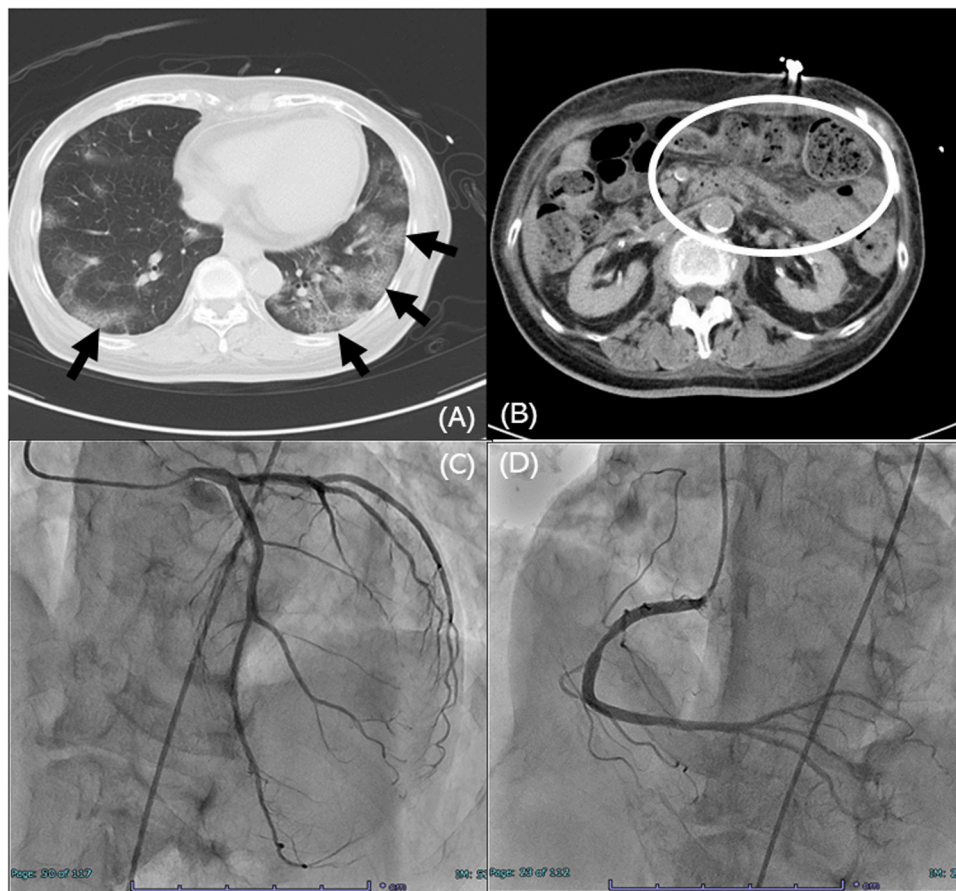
Thoracoabdominal plain CT and coronary angiography on the first day. CT revealed patchy ground-glass opacities and thickening of the interlobular septa in both lungs, as well as a small amount of ascites and edema in the fatty tissue of the mesenteric membrane, suggesting COVID-19-related pneumonia and enteritis (A, B; black arrows indicate pneumonia, white circles pneumonia enteritis). No significant stenosis was observed in the left and right coronary arteries (C, D).
